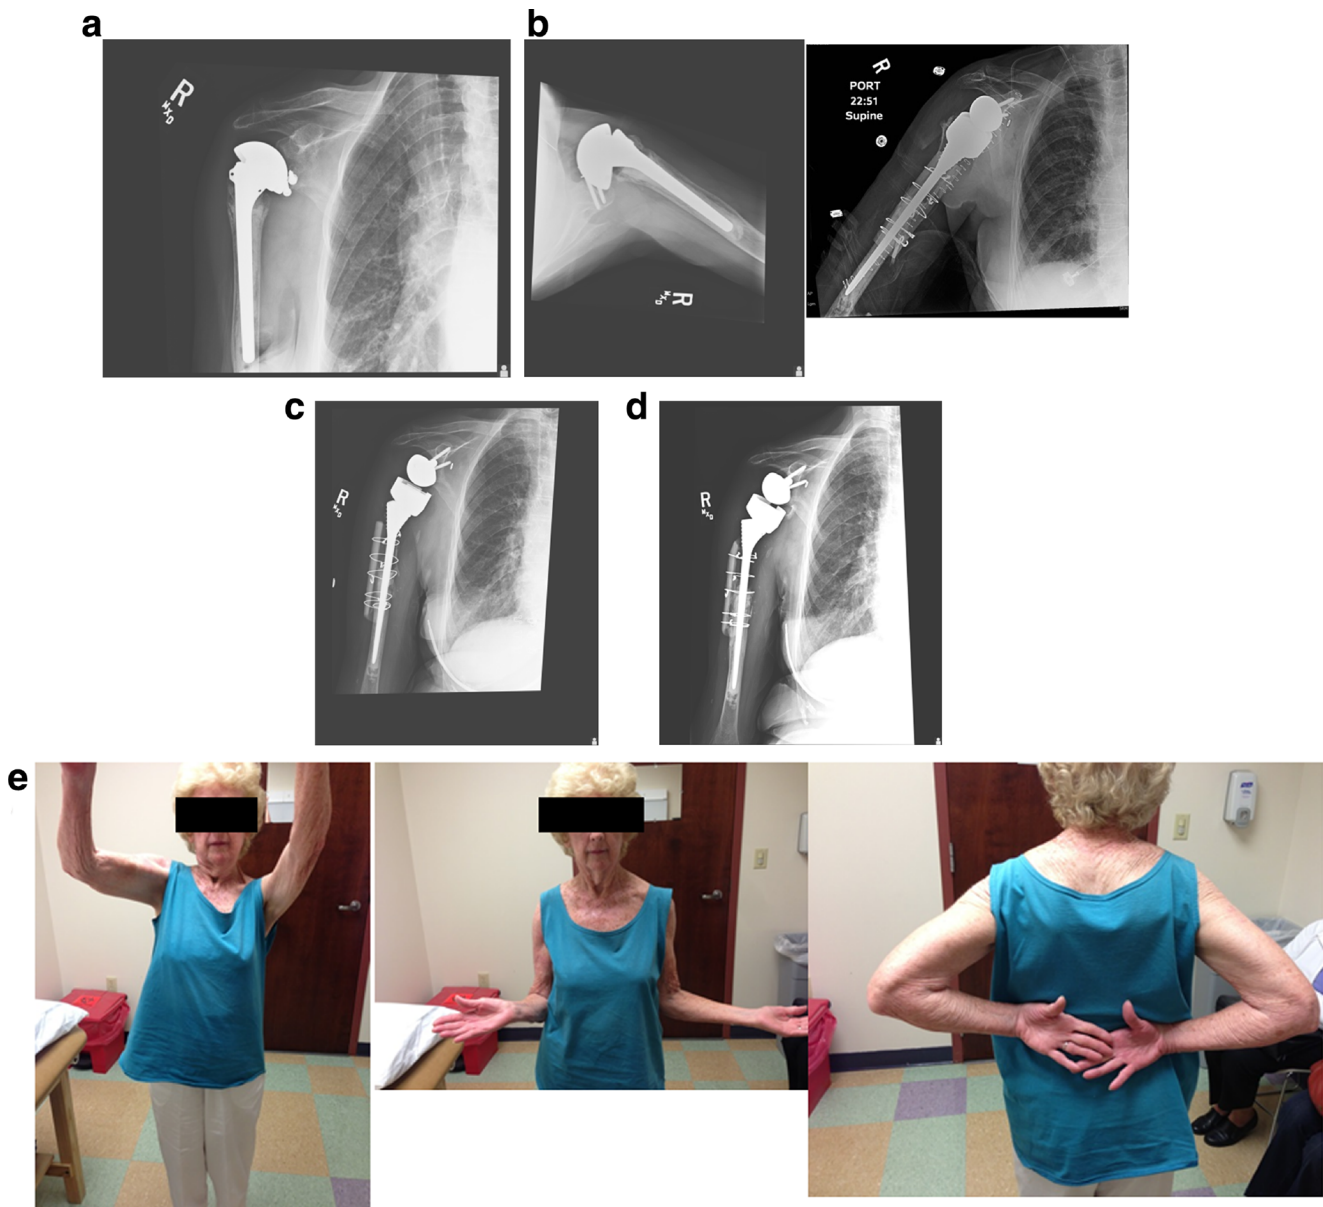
Case of a revision surgery for recurrent instability after hemiarthroplasty for proximal humerus fracture and attempt at allograft to the glenoid. a Presentation films with preoperative AP and axillary radiographs demonstrating a cemented hemiarthroplasty with tuberosity resorption and anterior humeral subluxation. b Revision to RSA was complicated by proximal humerus comminution after osteotomy for cemented implant extraction. Femoral strut allograft with cerclage wires
